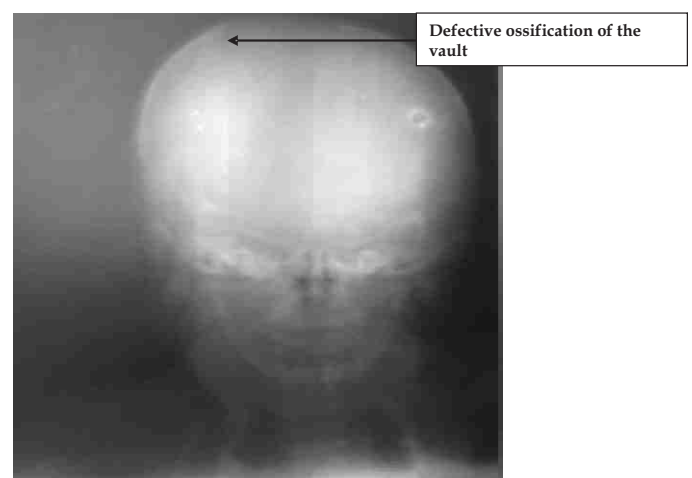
Plain Skull radiograph showing defective ossification of the vault in Case 1
